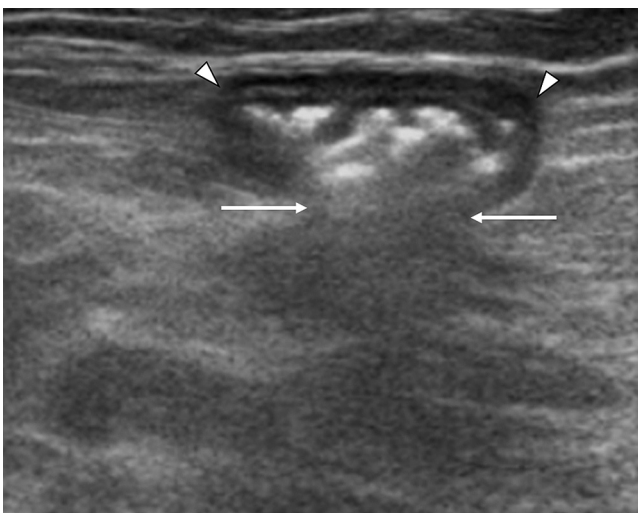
Incisional hernia. Transverse sonogram upper abdominal wall. The incisional hernia sac (arrowheads) that contains small bowel with gas, extending through a defect in the abdominal wall (arrows) at the site of previous surgery.
